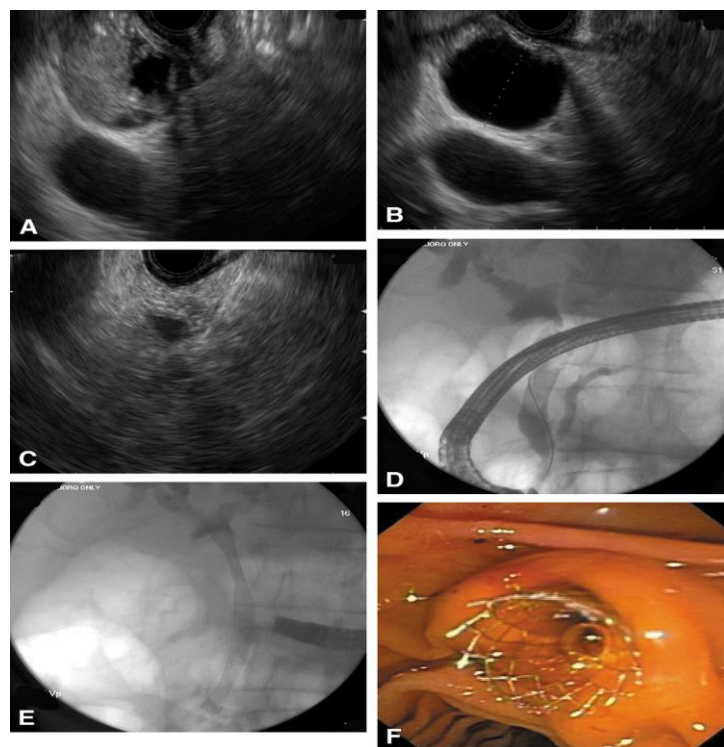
A, EUS showing a bile duct mass that was missed by a CT scan and MRI. B, Biliary dilation was present proximal to the stenosis. C, EUS-FNA was performed and was diagnostic of cholangiocarcinoma. D, ERC was performed during the same session, and cholangiography revealed a distal biliary stricture. E, F, A self-expandable metal biliary stent was placed. (Hoffman et al., 2008)
